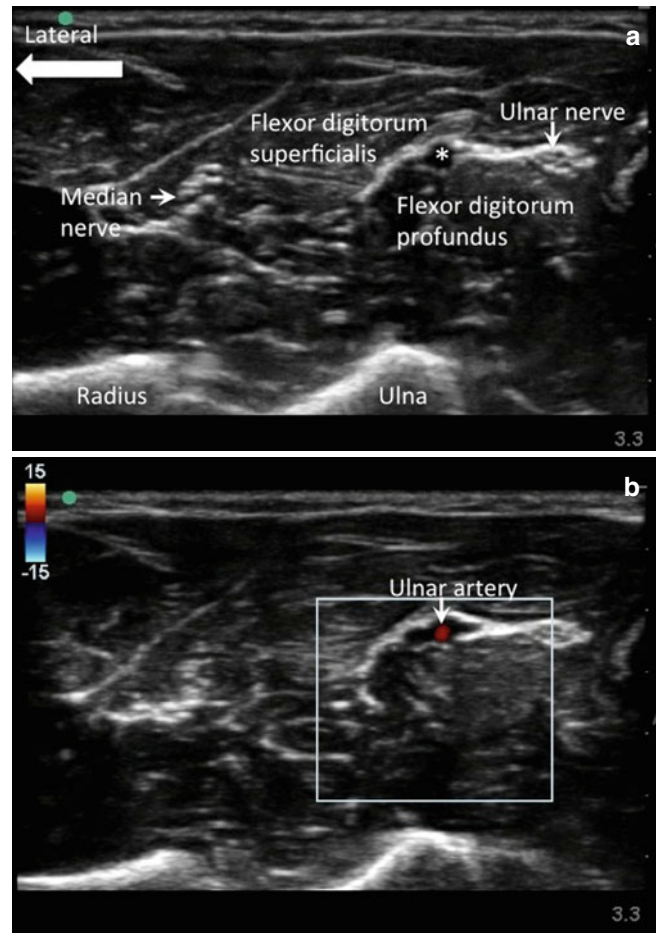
(a) Sonogram of ulnar nerve distal to the cubital tunnel. The ultrasound probe is placed on the ventromedial aspect of the forearm three fingerbreadths distal to the elbow. Please note that the ulnar artery (*) moves from medial nerve toward the ulnar nerve as the neurovascular bundles travel distally in the forearm. At this level, this is ideal for injection as the ulnar nerve is sandwiched between the flexor digitorum superficialis and profundus muscles and the ulnar artery is further from the ulnar nerve. (b) Doppler scan to show the ulnar artery (Reproduced with permission from Philip Peng Educational Series)
